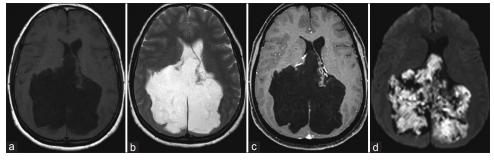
Preoperative MRI. Axial T1-weighted (a) and T2-weighted (b) MRI showing the low- and high-intensity signal of the lesion which seems to be pineal gland centered with extending from the posterior to the anterior fossa and insinuating into the brainstem, aqueduct, basal cisterns, and left cerebral peduncle. The lesion has no contrast enhancement (c). Diffusion-weighted imaging (d) shows the typical hyperintense and bright tones of the lesion. MRI – Magnetic resonance imaging
